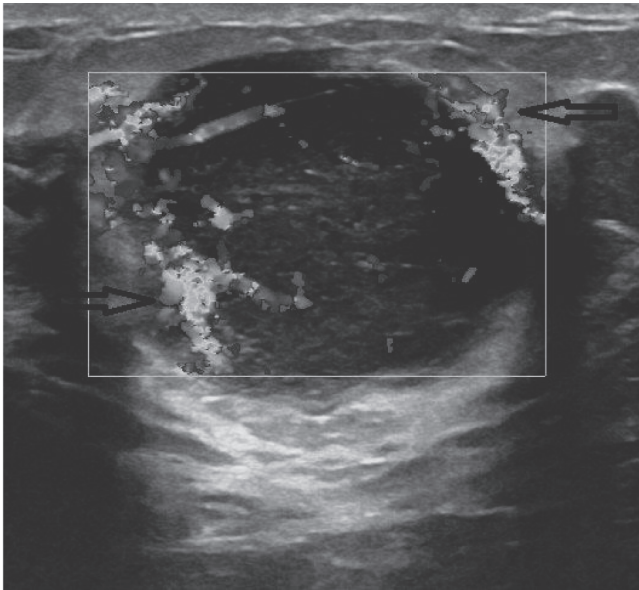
Ultrasound colour Doppler image of the lesion in the left breast with prominent perinodal vessels (arrows).
